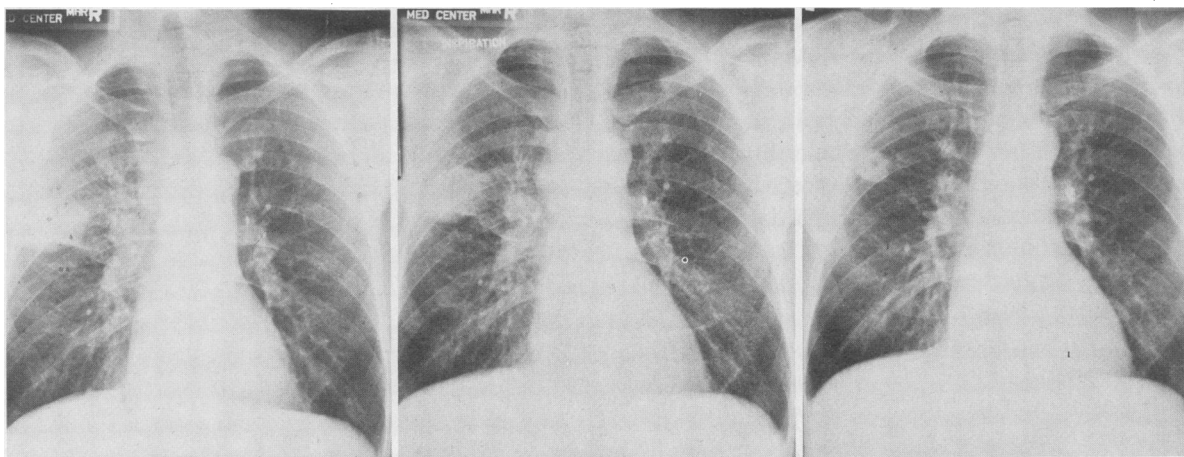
Left, the chest x-ray film on the first hospital day showed infiltration in the right upper lobe and an area of consolidation in its posterior segment. Center, on the eighteenth hospital day the right upper lobe infiltrations had decreased and a rounded density was forming. Right, a film six months after diagnosis showed a coccidioidoma with an area of rarefaction.
